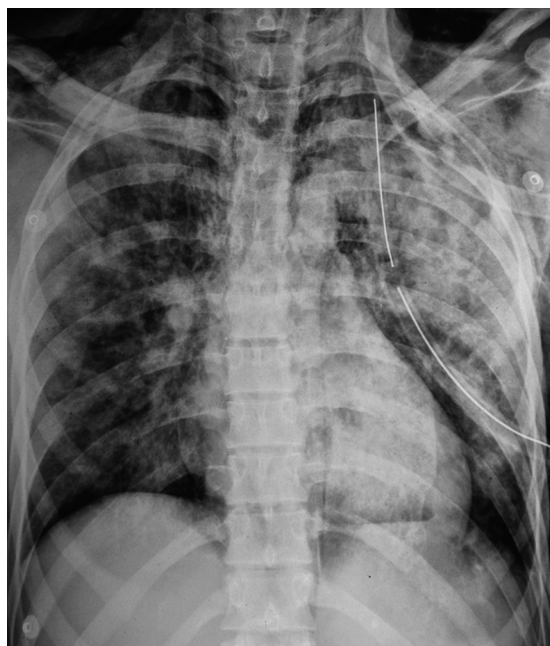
Chest radiograph shows massive subcutaneous emphysema and consolidation of the left lung.
